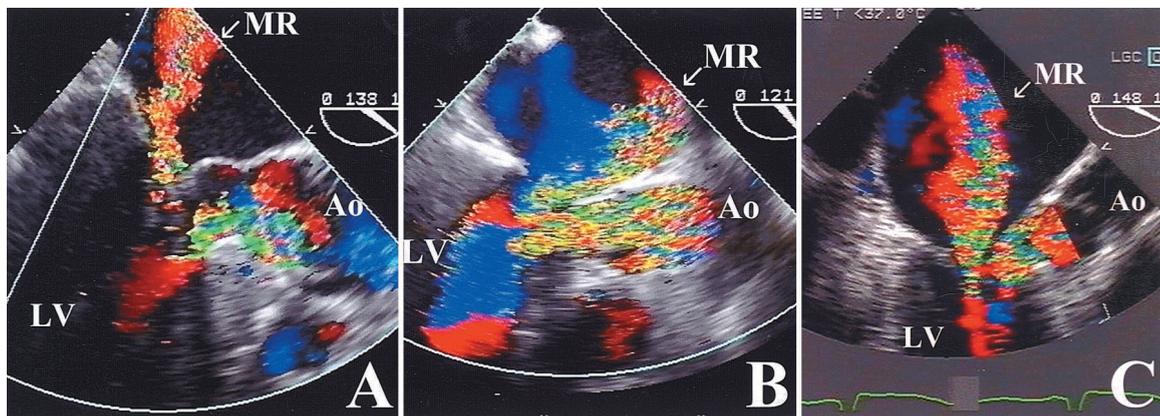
Transesophageal echocardiography images in three patients with hypertrophic obstructive cardiomyopathy showing: (A) Posteriorly directed mitral regurgitation jet (arrow) in a patient without independent abnormality of the mitral valve. (B) Anteriorly directed mitral regurgitation jet (arrow) in a patient with posterior mitral valve leaflet prolapse. (C) Centrally directed jet of mitral regurgitation (arrow) in a patient with mitral stenosis. Ao = aorta; LV = left ventricle; MR = mitral regurgitation.
